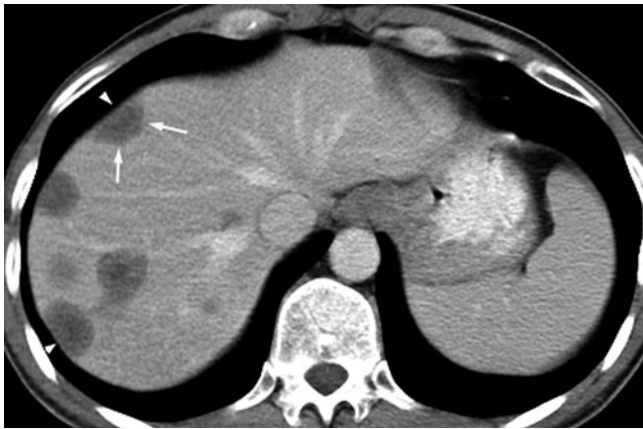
Epithelioid hemangioendothelioma. Contrast-enhanced CT (portal venous phase) shows multiple, predominantly peripherally based, hypodense lesions. Note that some lesions show a laminated appearance (*arrows*). Early development of capsular retraction is present, with flattening of the capsule overlying some lesions (*arrowheads*)
